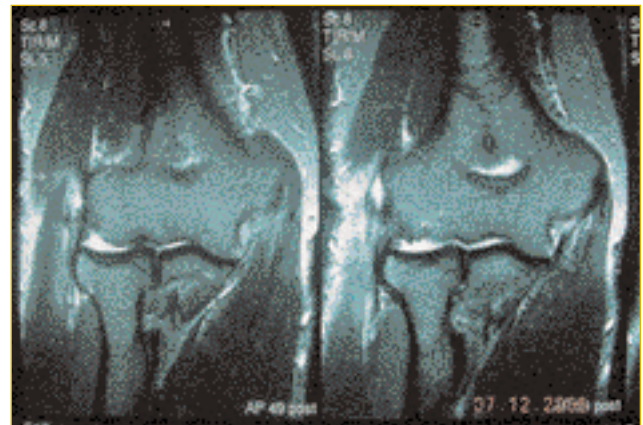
MRI of the right elbow of an amateur tennis player showing a tendon degeneration of the ECRB with a rupture.
